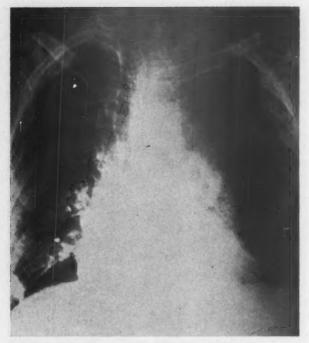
Clinical x-ray film with no calcification visualized in aortic arch.
